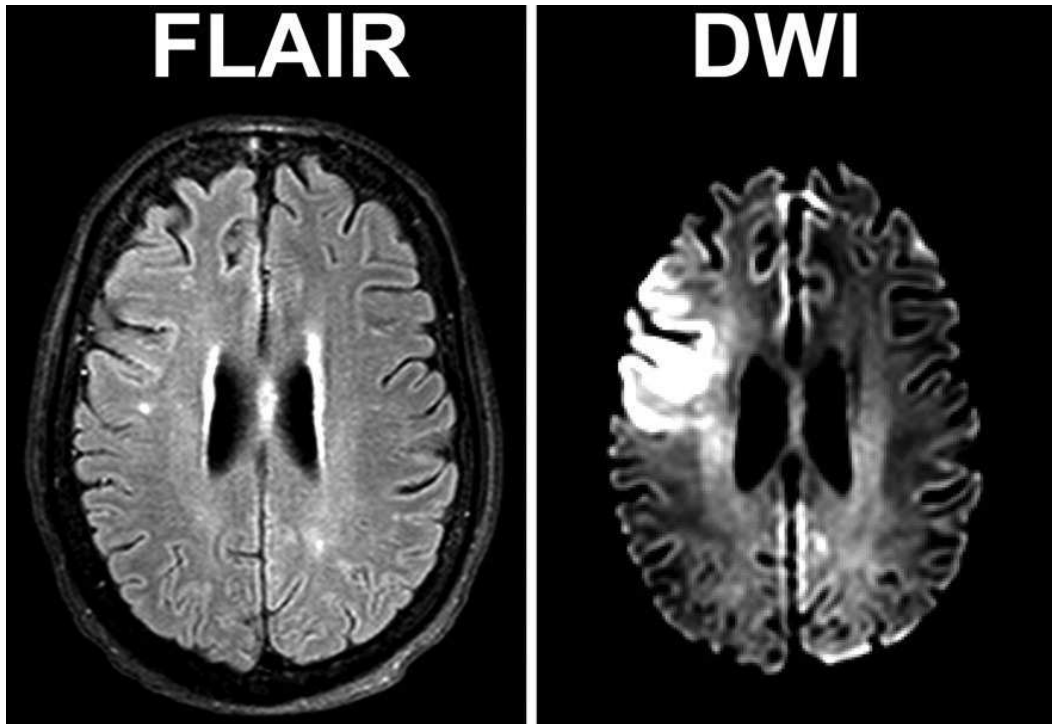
Comparison of FLAIR and dMRI. Comparison of FLAIR and dMRI (DWI stands for diffusion-weighted imaging) modalities in the detection of tissue changes in a patient with acute stroke (image courtesy of [Bokkers 2012]): dMRI (right) provides additional valuable contrasts with respect to the traditional FLAIR sequence (left).
